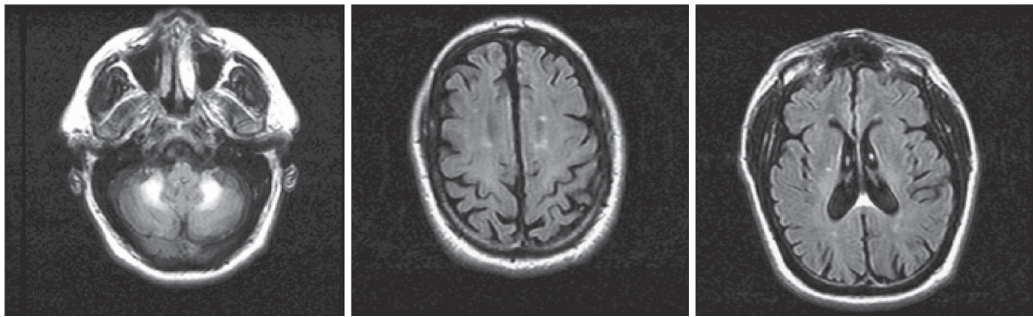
A. Axial flair MRI showing generalized atrophy and bilateral hyperintensities in the white matter and the splenium of the corpus callosum (white arrow). J. Axial flair MRI showing hyperintensity in both middle cerebellar peduncles (white arrows). K. Coronal T2-weighted MRI showing bilateral hyperintensity in the dentate nuclei (white arrows). L. Axial flair MRI showing hyperintense signals in the pons hyperintensities (white arrow).
